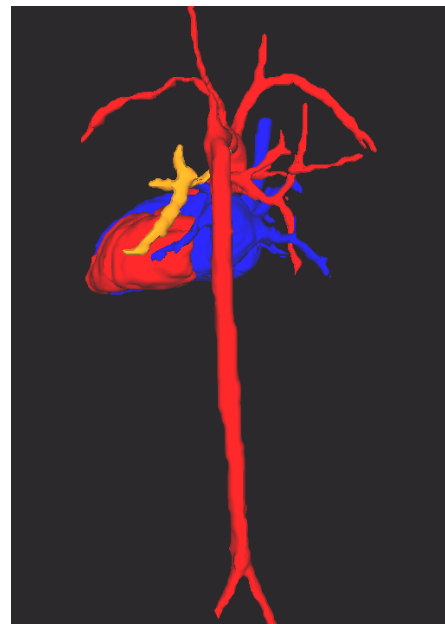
Rendered view of the heart and major vessels obtained by computerized post-processing of MR images in a patient with patent ductus arteriosus, a form of congenital heart disease (picture courtesy of Dr Marc Miquel, GKT School of Medicine, King's College London).
